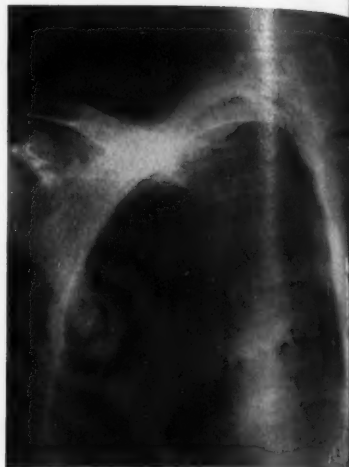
Case No. 2. Very small peripheral carcinoma at the right apex. On plain X-ray, erosion of the 3rd rib is not obvious.
